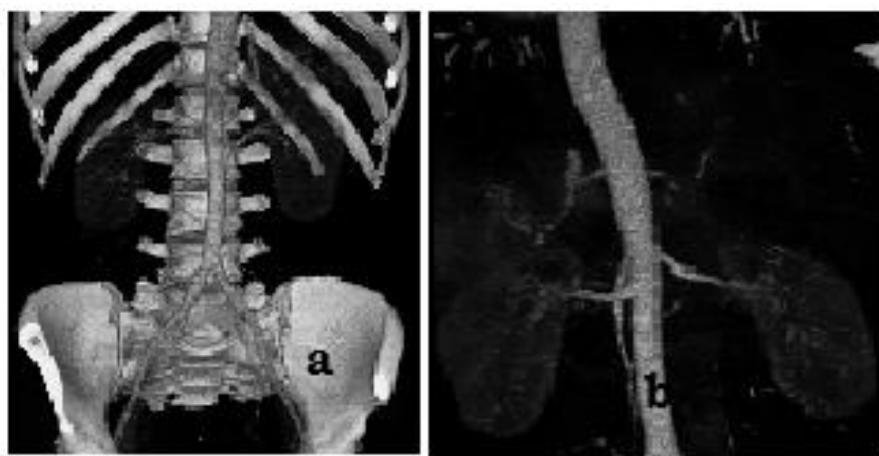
Multi-detection CT angiography showing a. The abdominal aorta as it lies on top of the vertebrae. b. The renal arteries arising from the aorta.
